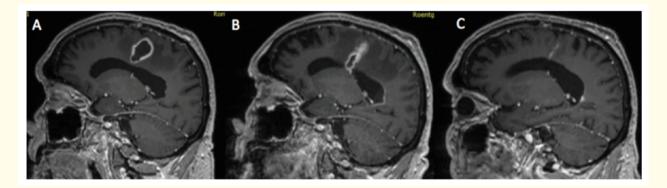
A: Sagittal MRI with contrast showing abscess in the frontal lobe two days following surgical drainage. B: Sagittal MRI with contrast 6 weeks after start of treatment showing abscess rupture into the ventricle and contrast enhancing ependyma indicating ventriculitis. C: Sagittal MRI with contrast showing almost absolved abscess after 12 weeks of treatment.
